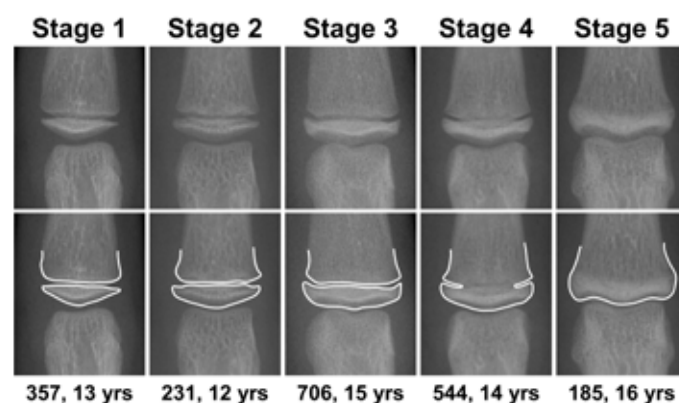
Representative radiographs for each third finger middle phalanx maturation stage according to the reference standard. Middle phalanx maturational stages showed without (upper) and with (lower) corresponding tracing. Numbers at the bottom represent the Burlington Growth Study files subjects and age.
